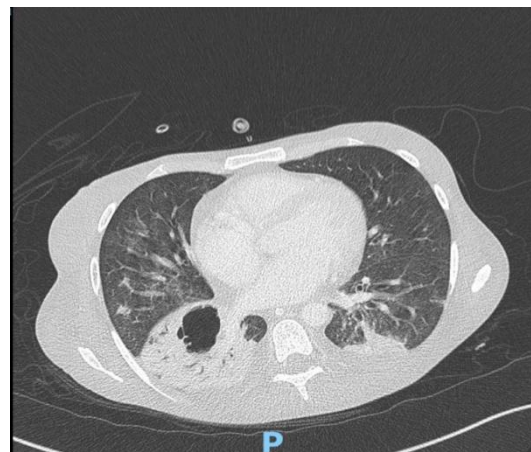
Chest contrast-enhanced CT large intraparenchymal cystic lesion in the right lower lung lobe.
